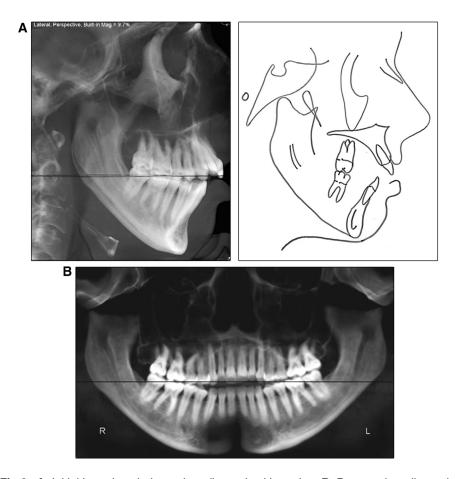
A, Initial lateral cephalometric radiograph with tracing. B, Panoramic radiograph.
